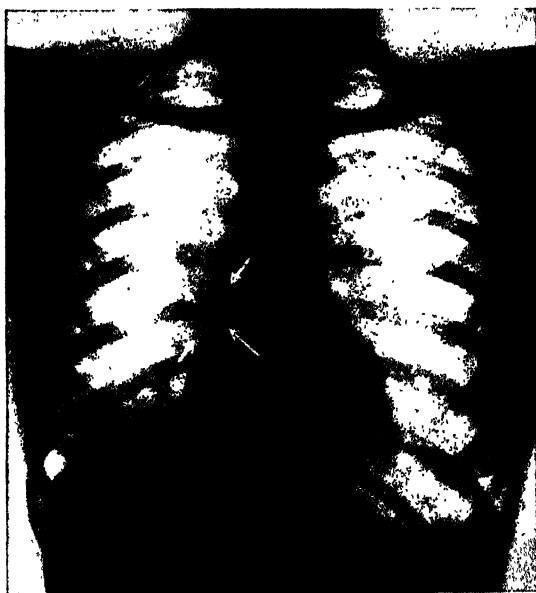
(CASE No. Fbdy, 1558.) A roentgenogram of a woman aged 29 years showing the pathological condition in the right lung due to the overlooked presence of a portion of safety pin for a period of fifteen years. Complete recovery followed peroral bronchoscopic removal, notwithstanding 15 years of invalidism. The bronchoscopic removal required only 10 minutes and 18 seconds, and was done without general anesthesia. (Surg., Gyn. and Obst.)
